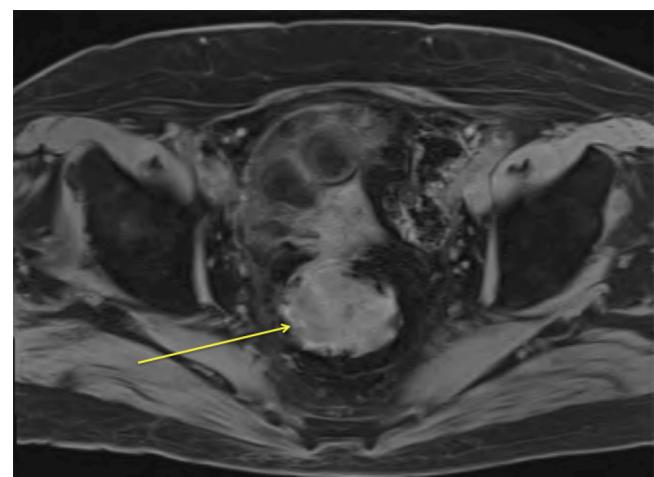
Axial fat-saturated T1 weighted MRI at the level of the rectum. There is an endoluminal soft tissue mass (Yellow arrow) which is diffusely high signal, due to the melanin content of the tumour.
